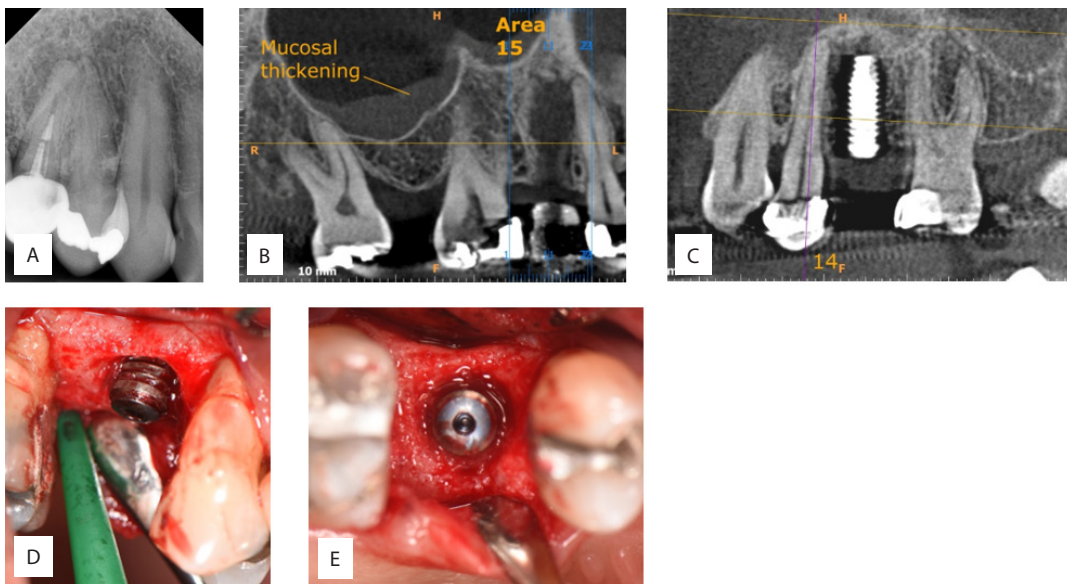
(A) Periapical radiograph of tooth 15 with inadequate root filling with periapical radiolucency; (B) CBCT of edentulous tooth 15 region at four months after extraction before implant placement; (C) CBCT of implant 15 and tooth 14 showing an osteolytic region with ill-defined margin originating from disto-apical surface of tooth 14, extending to the mesial surface of implant replacing tooth 15; (D) Buccal view shows presence of gap surrounding 15 implant after flap full-thickness flap elevation and one third of implant length is exposed; (E) Occlusal view shows a gap between the implant surface and surrounding alveolar bone.
